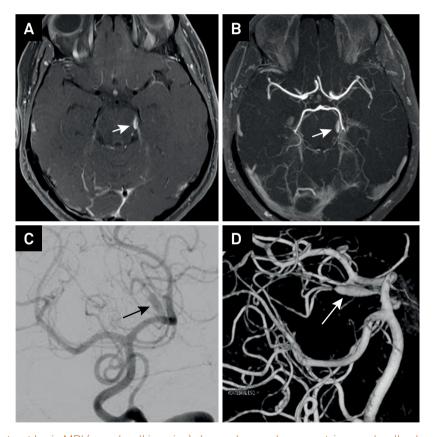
Axial post-contrast brain MRI (vessel wall imaging) shows abnormal asymmetric vessel wall enhancement in left superior cerebellar artery (A); axial 3D-TOF MRI angiography shows segmental ectasia in the left superior cerebellar artery (B). Digital subtraction angiogram of the left vertebral artery and 3D reconstructions confirmed dissecting superior cerebellar artery aneurysm (lateral pontomesencephalic segment) (arrows) (C and D).
